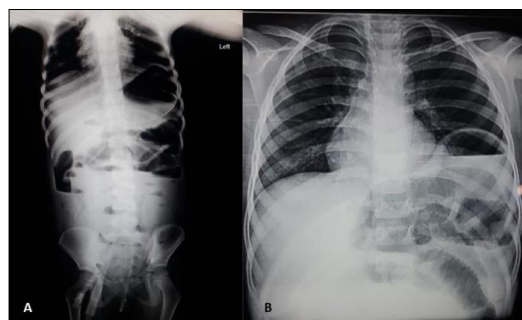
1B: Radiograph of abdomen and chest, air-fluid levels in the abdomen and elevated left hemidiaphragm.
